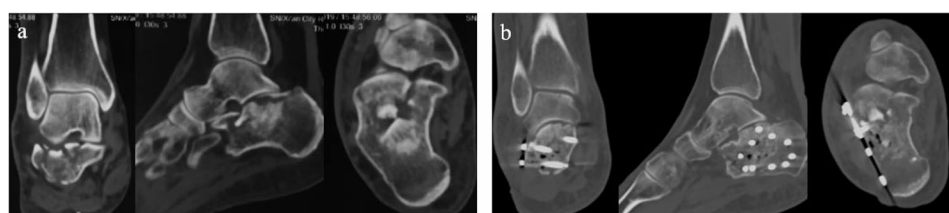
Preoperative and postoperative CT image comparisons of the patient. (a) Preoperative coronal, sagittal, and transverse CT images of the patient's calcaneus show fragmentation of the subtalar joint surface, poor smoothness, significant compression of the calcaneus height, lateral bulging of the calcaneal outer wall, and widened calcaneus. (b) Postoperative coronal, sagittal, and transverse CT images of the patient's calcaneus show a well-aligned subtalar joint surface post-reduction, with good anatomical matching and restored calcaneal width
